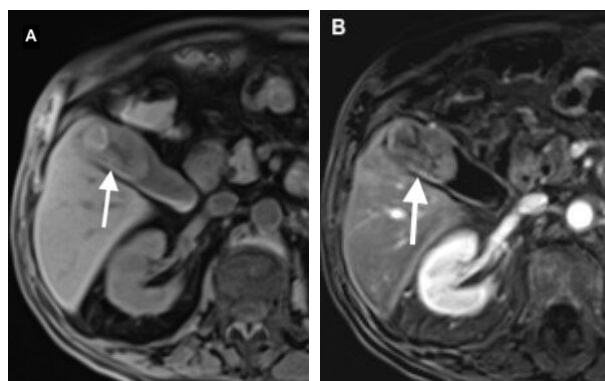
Axial fat-suppressed T1-weighted MRI without (A) and after (B) contrast administration demonstrates a heterogeneous gallbladder mass focally hyperintense (A) and enhancement (B).
